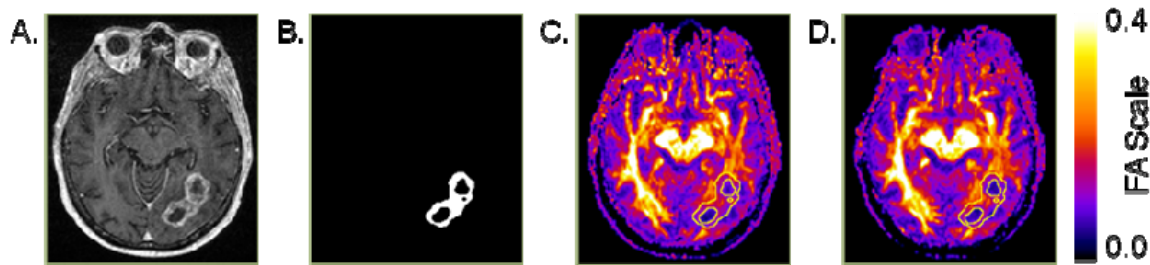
Contrast-enhanced T1-weighted SPGR image (A) demonstrating left temporoparietal glioblastoma multiforme was segmented to isolate tumor-related enhancement (TRE; B). In this example, mean fractional anisotropy (FA) was calculated within TRE on days 1 (C) and 3 (D).
